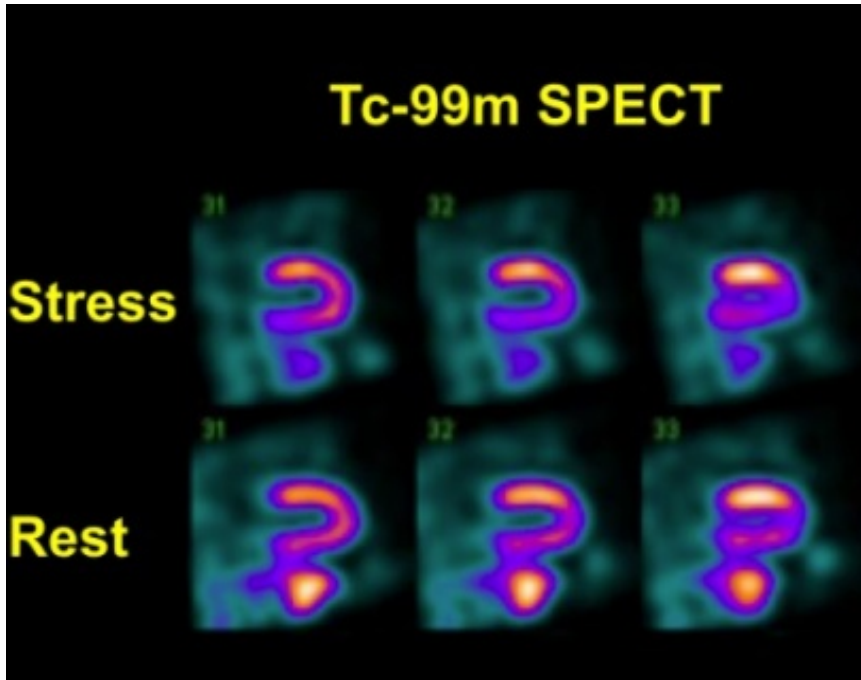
Cardiac SPECT image [41]
